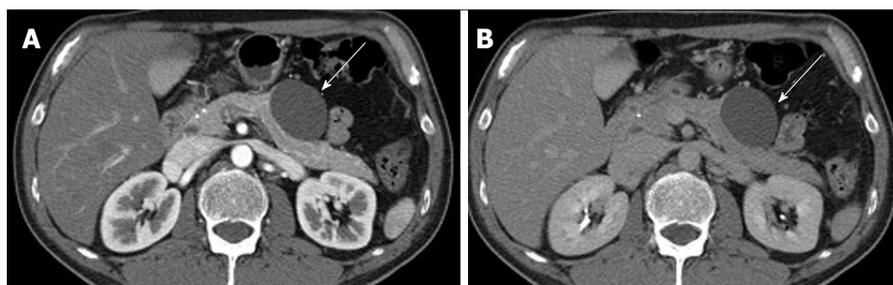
A 40-year-old female with oligocystic serous cystic neoplasm (unilocular). A: The pancreatic parenchymal phase of an axial contrast enhanced-computed tomography shows a unilocular cystic mass arising from the pancreatic body (arrow); B: The equilibrium phase shows no cyst wall enhancement (arrow).
